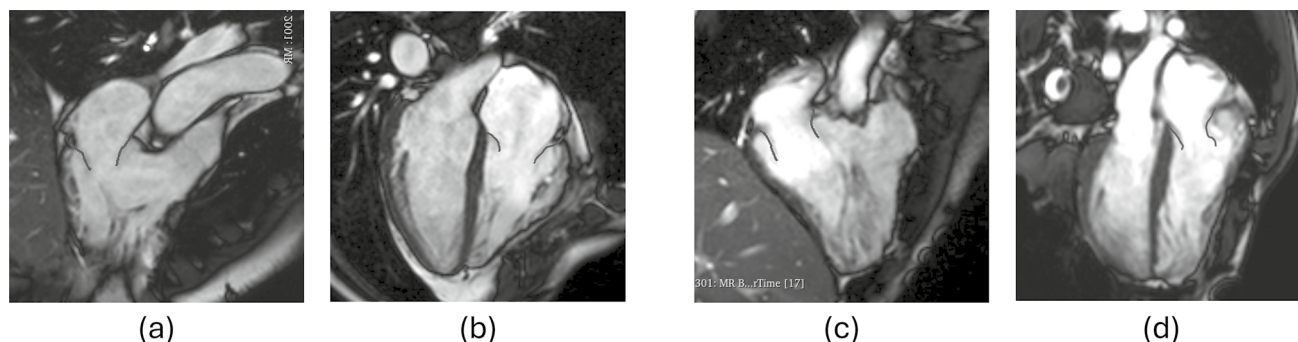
Intersection of the reconstructed TV surfaces (green line) with the cine MRI planes for the healthy subject (a and b) and the repaired-ToF patient (c and d). Images a and c: RV inflow views;
